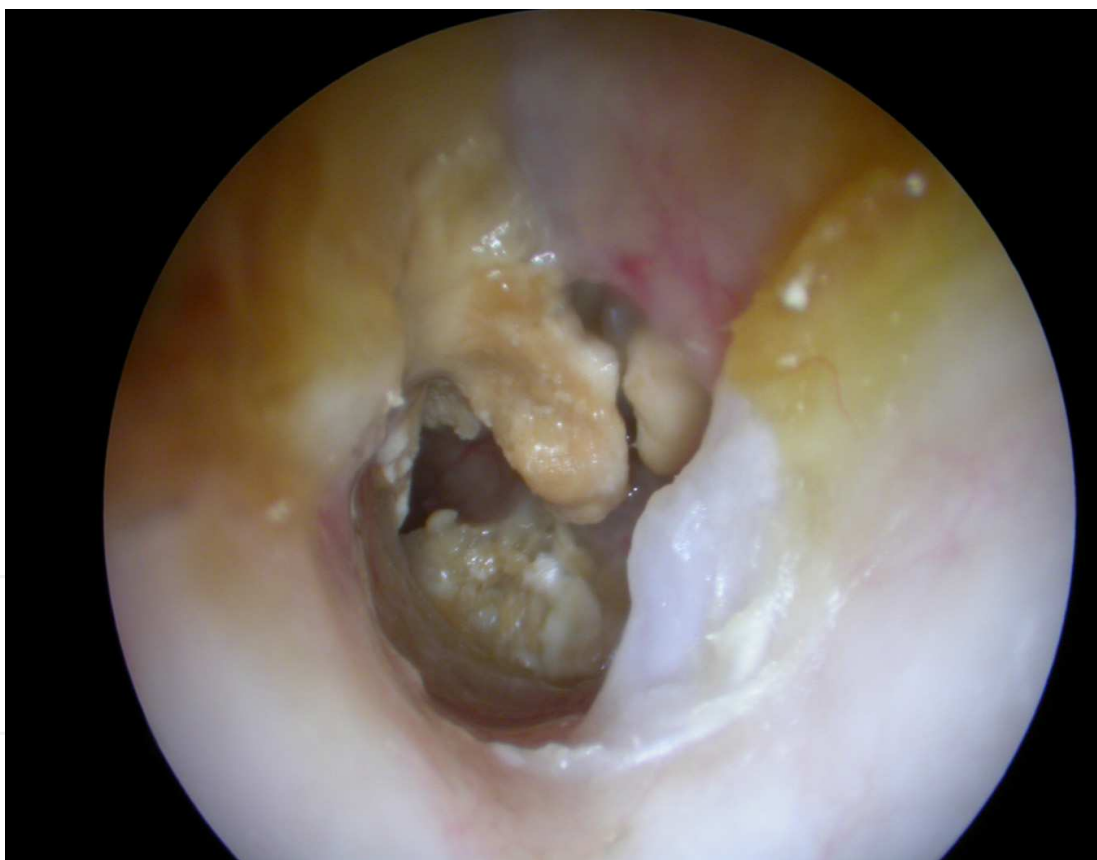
Endoscopic view of the left external and middle ear showing osteo-radionecrosis. This 60 year old woman had radiotherapy for NPC 15 years ago and had remained disease free since. She presented with chronic left ear discharge 12 years after radiotherapy. Examination showed necrotic in the external ear canal and middle ear. CT scan showed that the bony lesions did not involve the rest of the temporal bone. She was closely followed up with regular aural toilet and topical antibiotics. She was not keen for other treatment options like hyperbaric oxygen and sequestrectomy.
